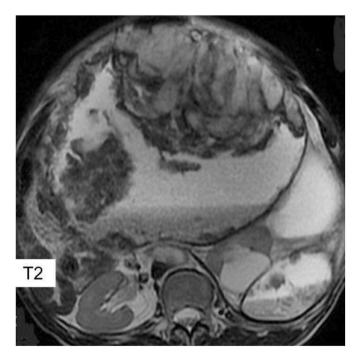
T2-weighted image of an MRI showing a heterogeneous signal intensity of the tumor component with a high signal intensity cystic lumen.
